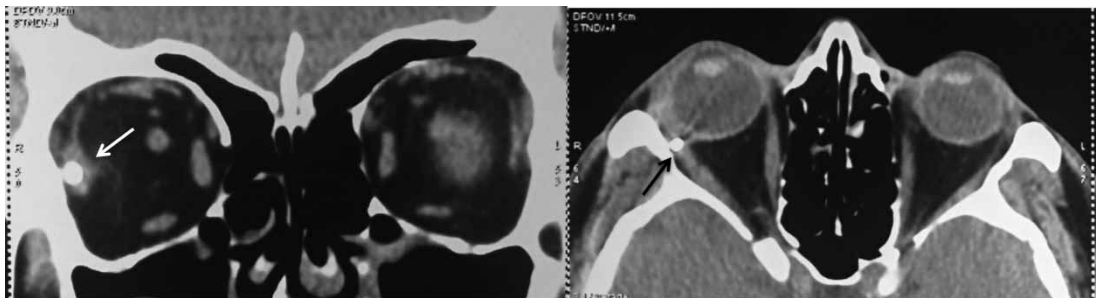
CT scan of the orbits revealing a hyperdense foreign body in the substance of the lateral rectus muscle posteriorly (white arrow), in close proximity to the macula (black arrow).
